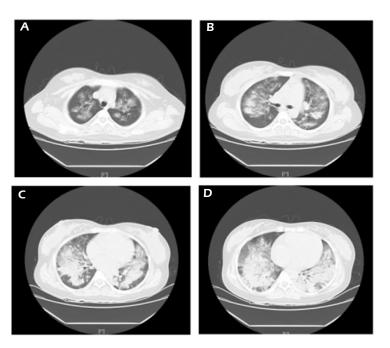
CT scan of the lungs at admission. A, Transjugular notch cross-section. B, Horizontal cross-section through trachea bifurcation. C, Cross section through both inferior pulmonary veins. D, Cross-section through phrenic venal foramen.
